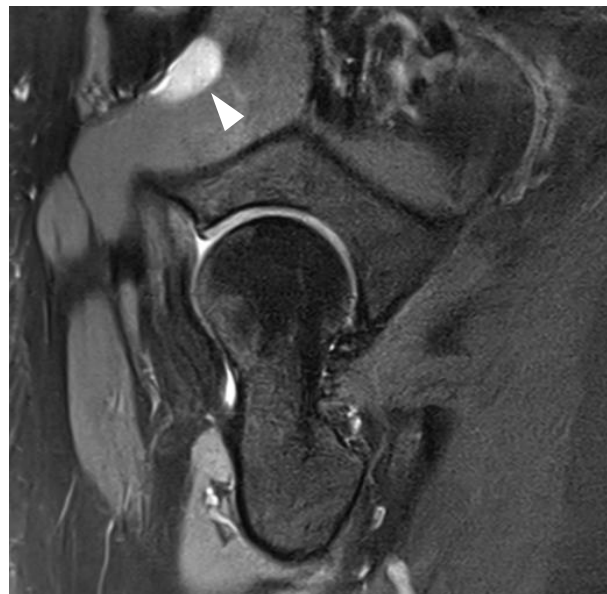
Coronal-oblique T1-weighted fat-suppressed post-contrast MRI of the right pelvis aligned along the femoral neck axis (white arrow head)
